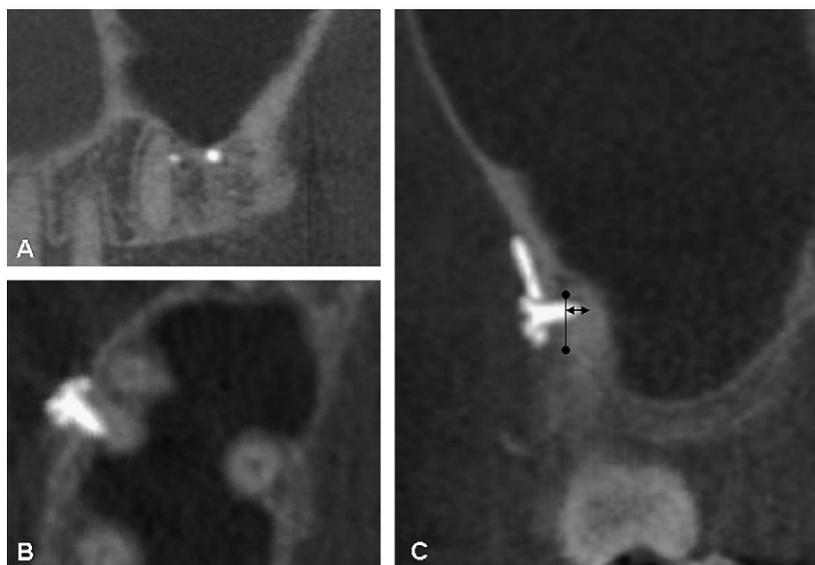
CBCT view of the miniplate showing root penetration of the miniscrew: A, sagittal view; B, axial view; C, frontal view.
